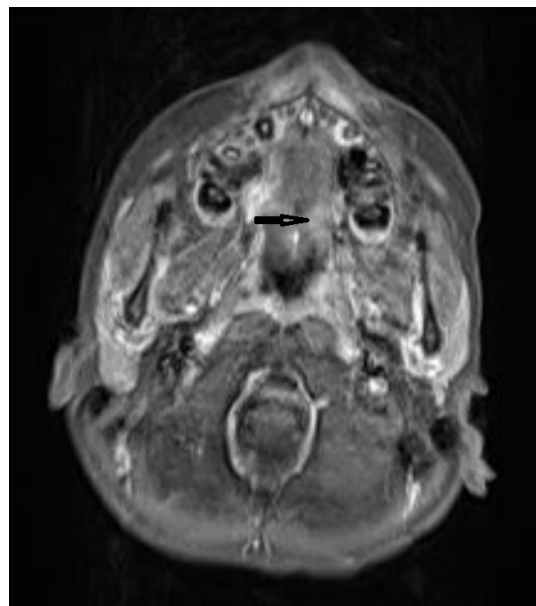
MRI showed a mass at the posterior right side of the hard palate
